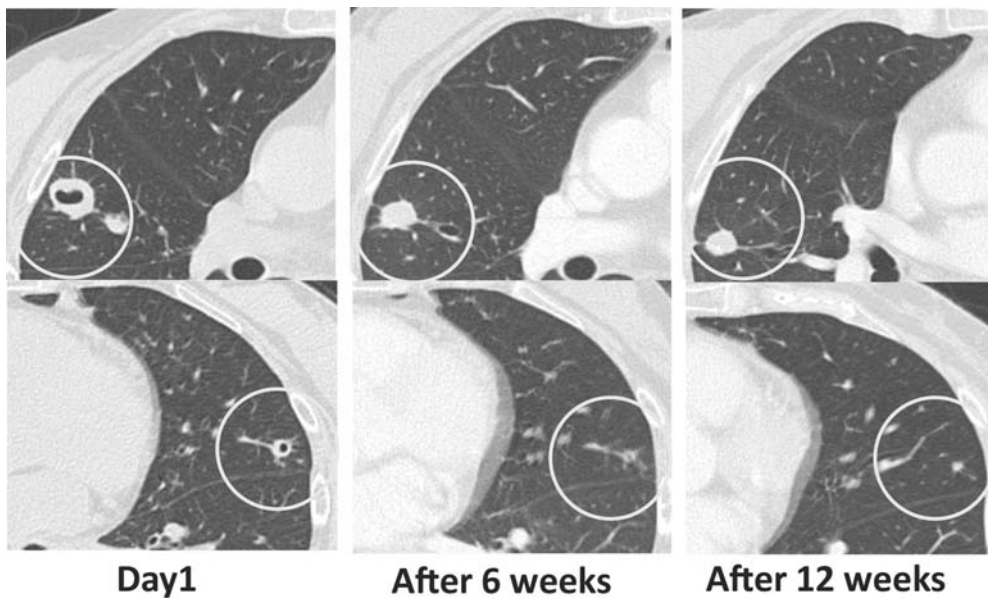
Chest CT examination after the use of antifungal drugs.
